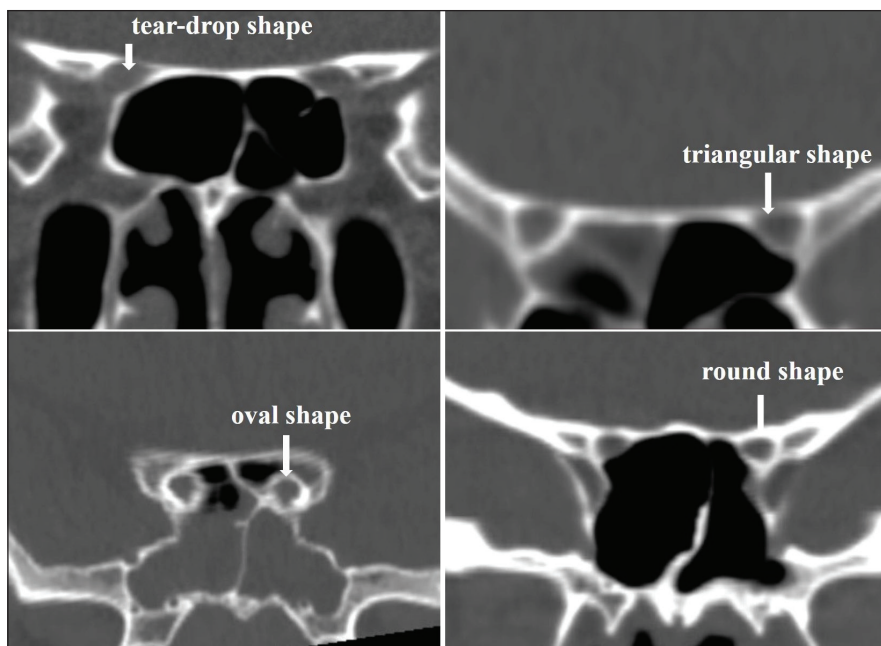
Aperture shapes on coronal CT images.
